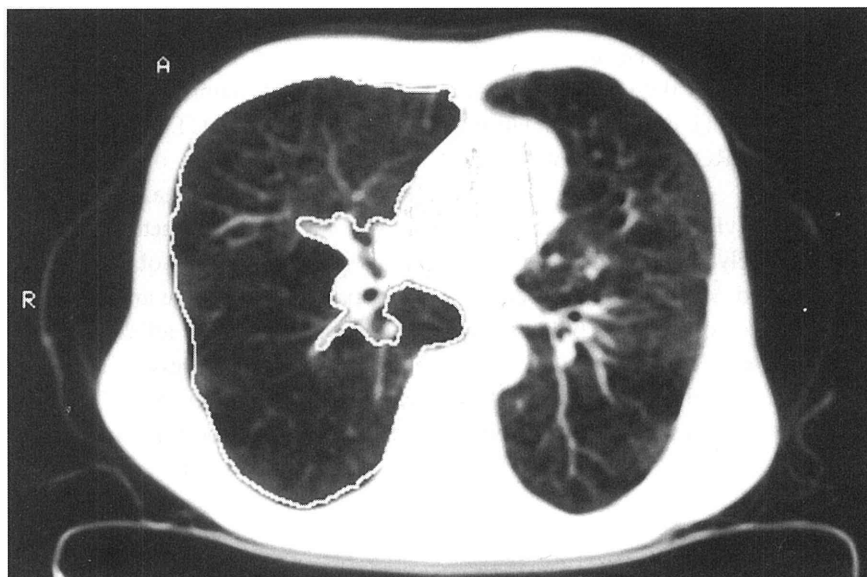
Regions of interest (ROIs) for multislice scanning were selected from the anatomic levels of the carina in the right upper lung field. Several identical slices were taken from 8 slices each from the inspiratory and expiratory phases. We calculated CT values in the ROIs with 8 slices each. The average CT values in the ROIs (AvROI) were obtained during the inspiratory phase (inAvROI) and the expiratory phase (exAvROI).
